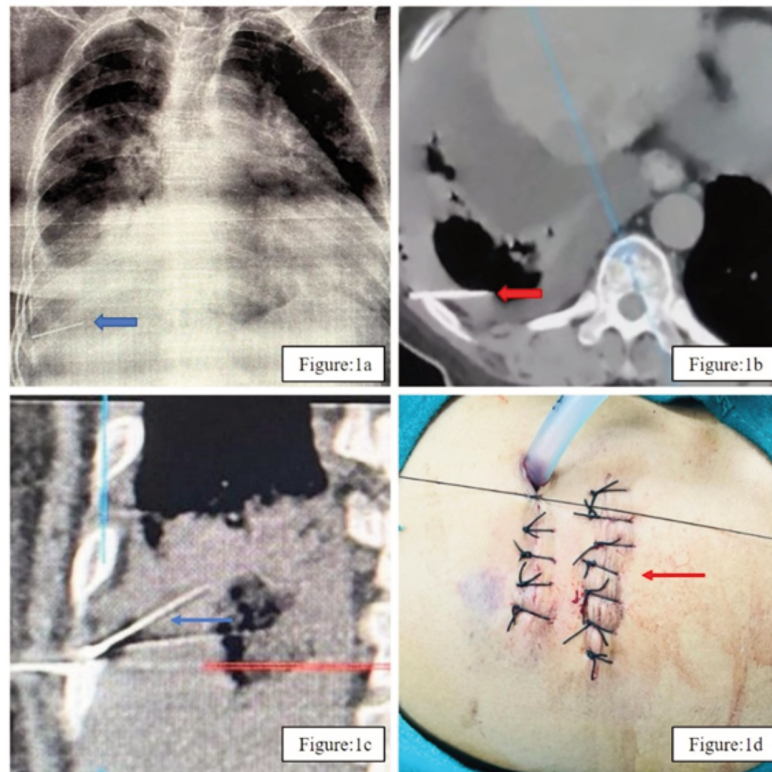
a) A foreign body in chest radiography (blue thick arrow); b) shows an axial Computed Tomography (CT) of the thorax image with the needle in the pleural cavity and head in muscular plain (thick red arrow); c) shows sagittal section of the CT with needle embedded in lung with head in the muscular plain (thin blue arrow); d) shows scar and sutures post-surgical exploration of muscular plain (thin red arrow).
